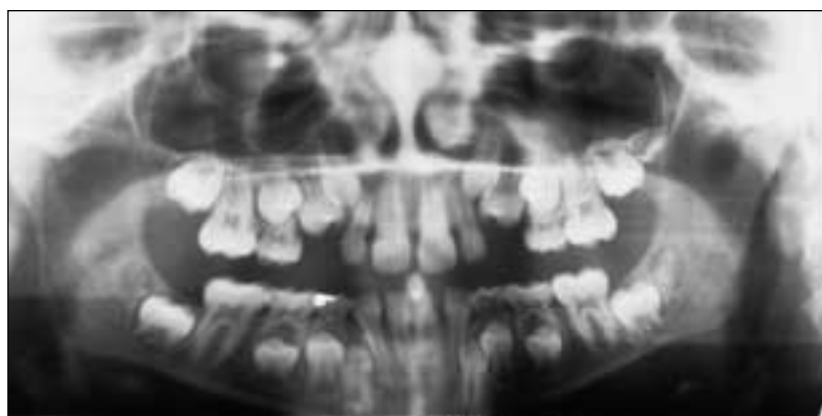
Progress panoramic radiograph. Patient was 12 years 2 months of age.
